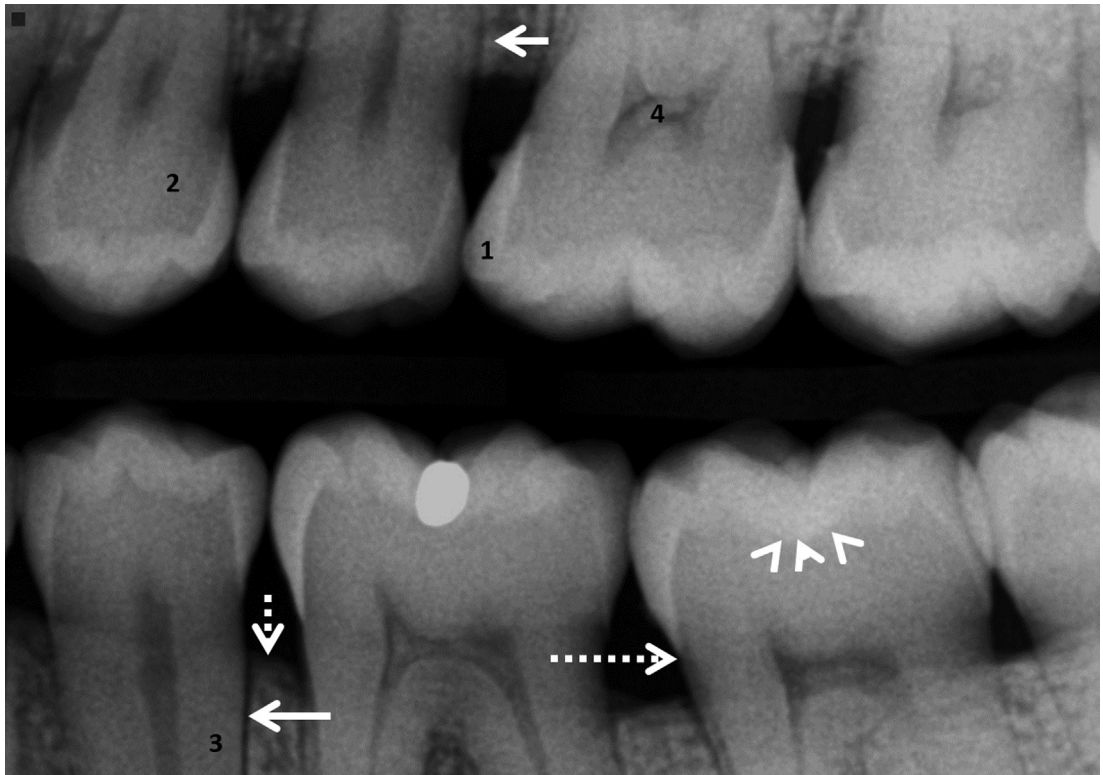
Intraoral left molar bitewing radiograph labeled showing enamel (1), dentin (2), cementum (3), pulp (4), lamina dura (*short white arrow*), periodontal ligament space (*long white arrow*), crest of the alveolar bone (*short dotted arrow*), dentinoenamel junction (*arrowheads*), and cementoenamel junction (*long dotted arrow*).
